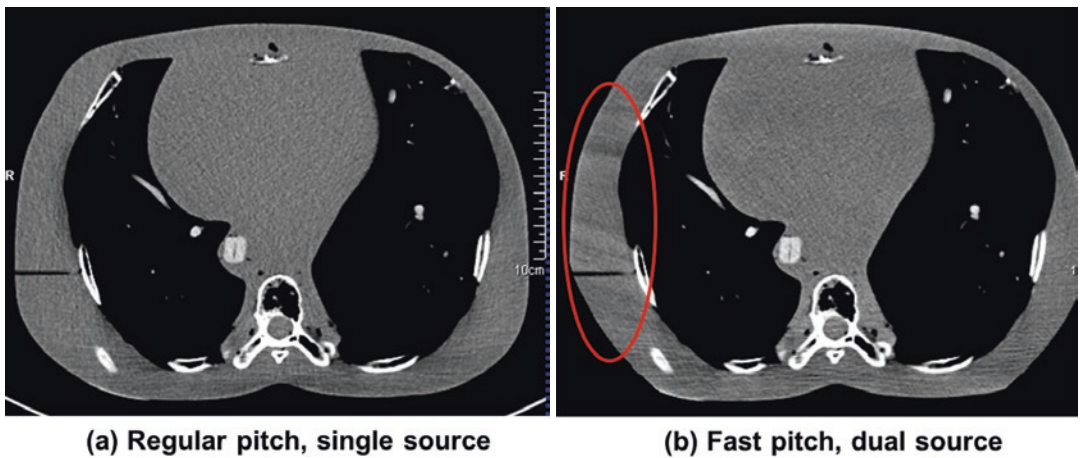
Fast pitch scan mode with dual x-ray sources generates more severe helical artifacts than regular pitch mode with a single x-ray source. (Reprinted with permission from Weber et al. [67])
